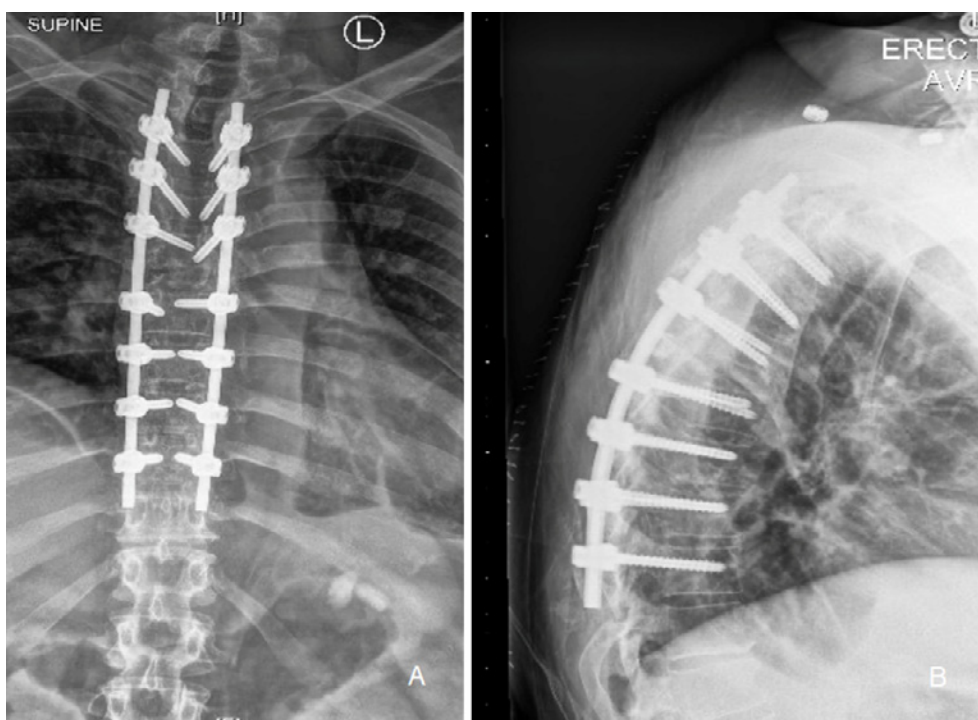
Anteroposterior and lateral postoperative x-rays showing posterior decompression, fusion, and shortening procedure.
